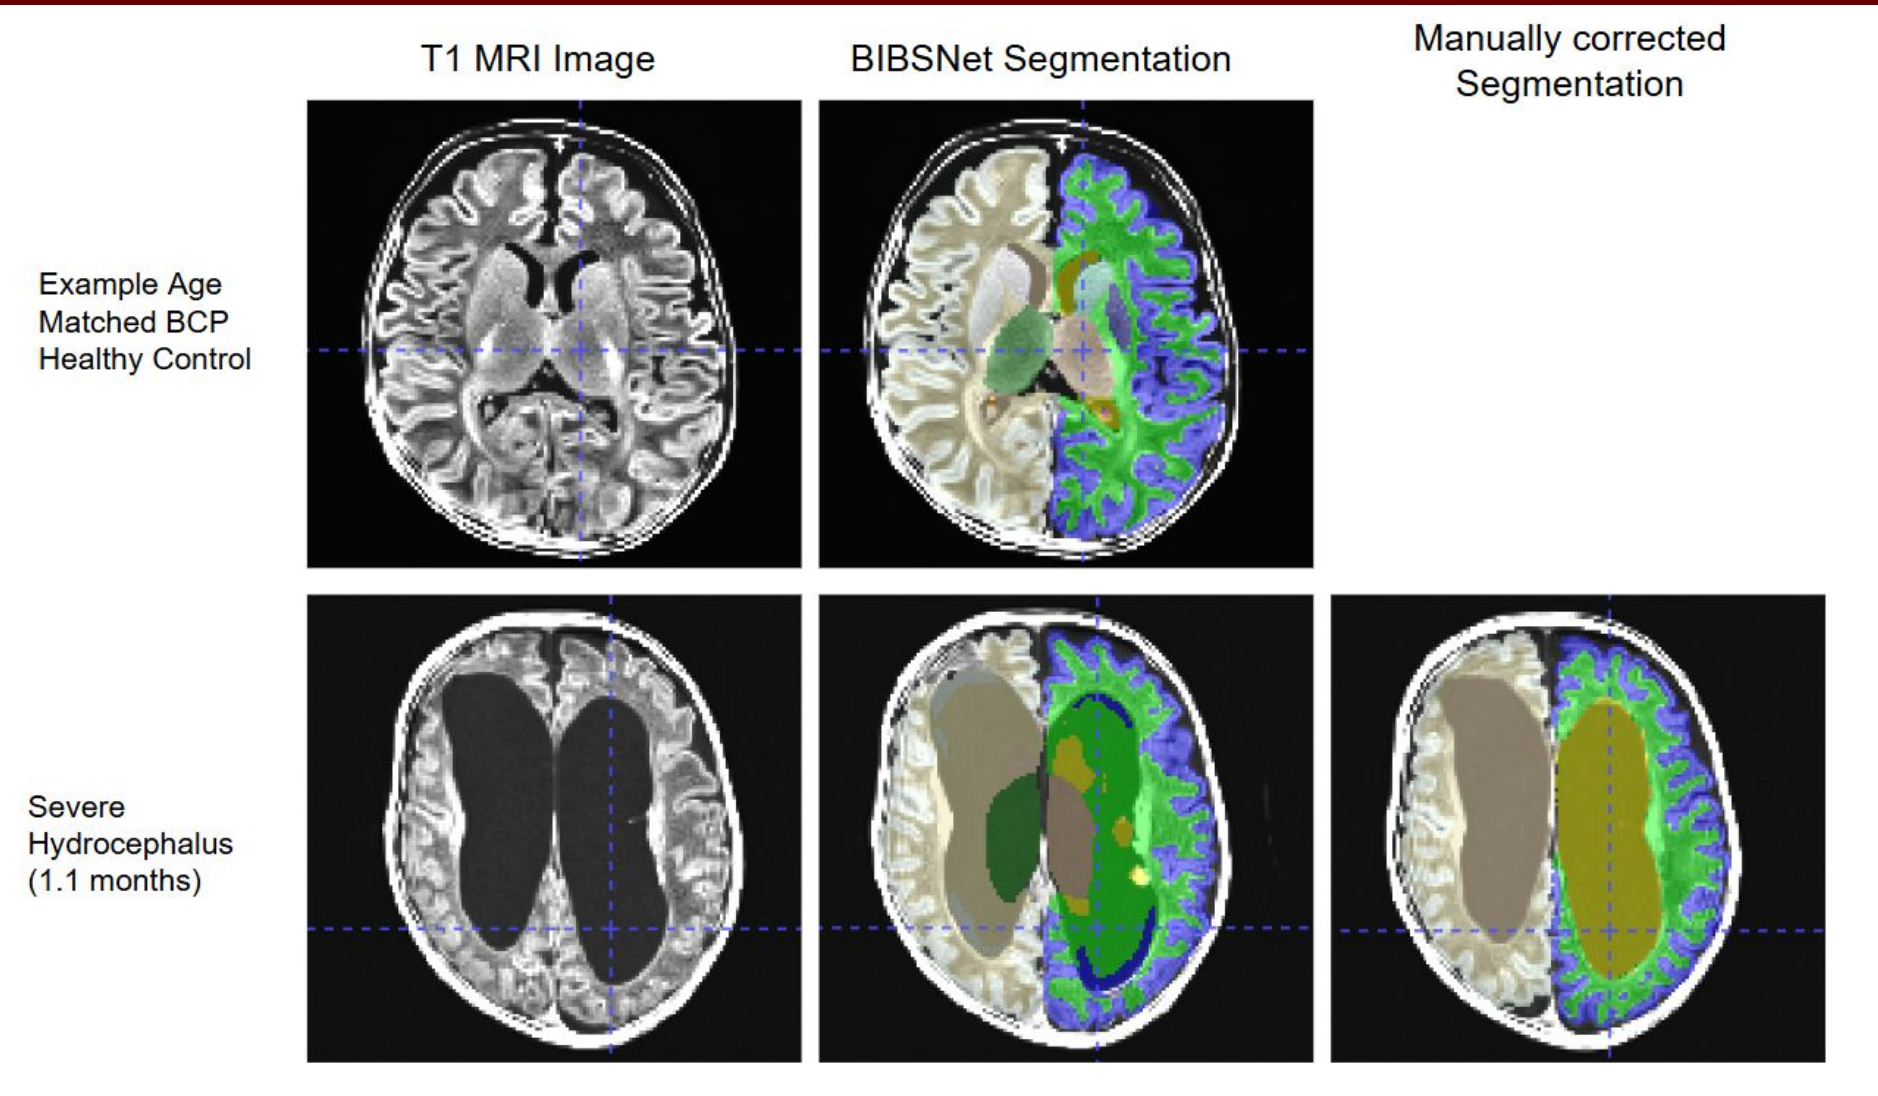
Axial view of T1 MRI image and corresponding segmentations of the clinical participant with Severe Hydrocephalus (1.1 months) compared with an example of an age matched BCP healthy control.
